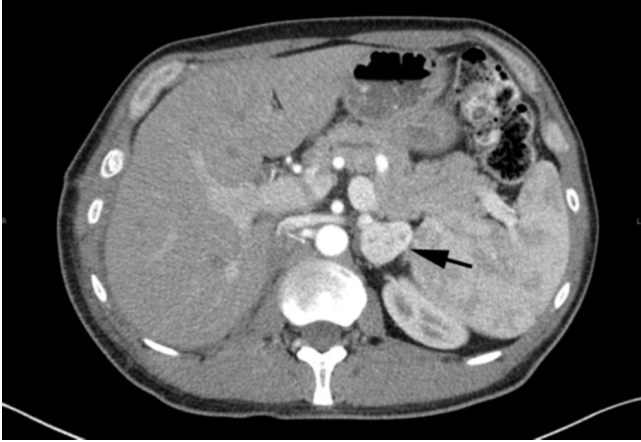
50-year-old man with renal-cell carcinoma. Post-contrast axial CT image demonstrates enhancing left adrenal lesion (arrow).
